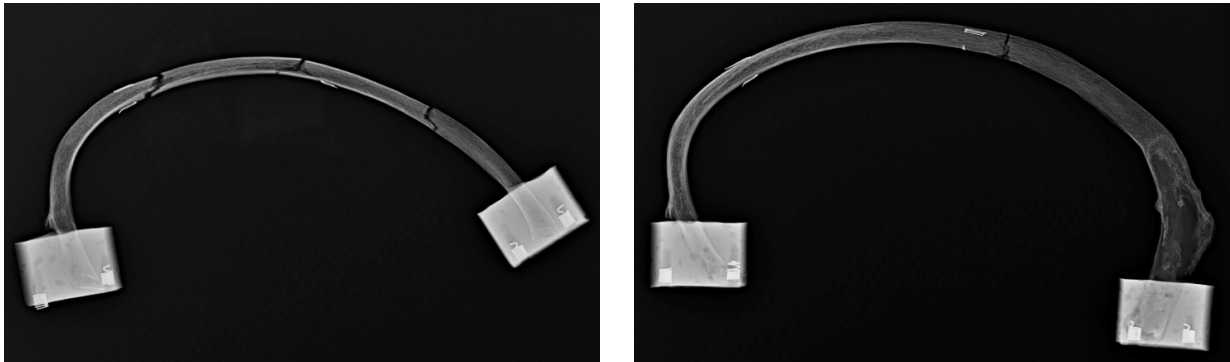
Pair 6 rib (left) and rib+CC (right) post-test x-rays (not to scale)
